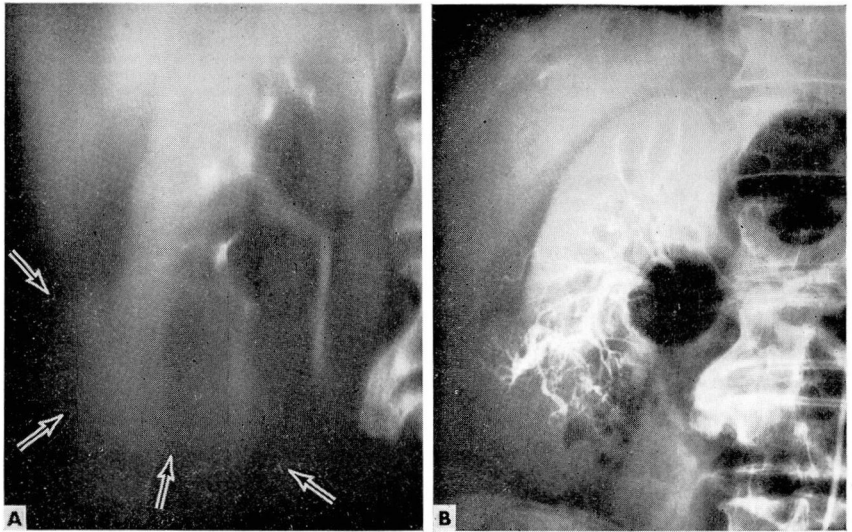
A, intravenous urogram (laminagraphic view) demonstrates smooth contour of tumor deformity arising from the lower pole of the right kidney. The radiographic diagnosis was that of a probable cyst. B, renal angiogram demonstrates a typical renal cell carcinoma arising from the lower pole of the right kidney. The diagnostic value of an angiogram is demonstrated here, as all clinical evidence favored a diagnosis of simple renal cyst.
